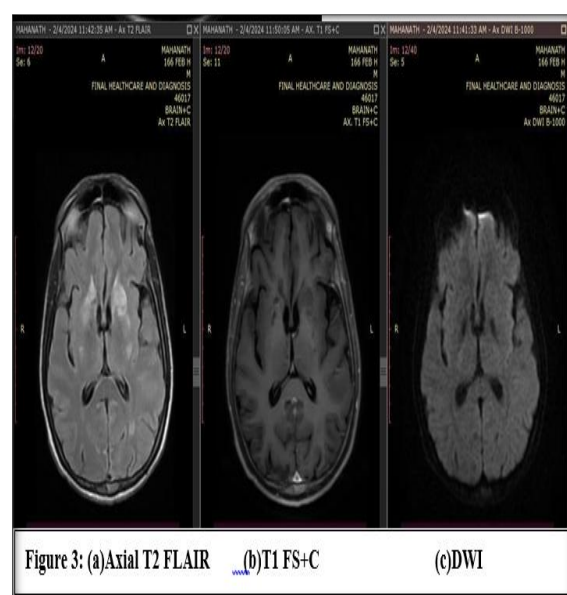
(a)Axial T2 FLAIR (b)T1 FS+C (c)DWI
